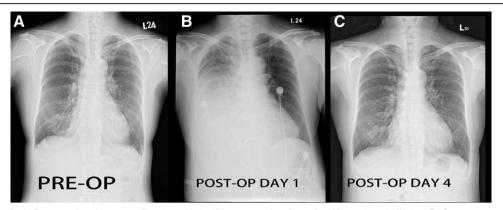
Chest radiograph. A, Preoperative chest x-ray film showed significant costophrenic angle without pleural effusion. B, On postoperation day 1, it showed right massive pleural effusion and lung atelectasis. C, On postoperation day 4, it showed in the absence of right pleural effusion and significant costophrenic angle.
